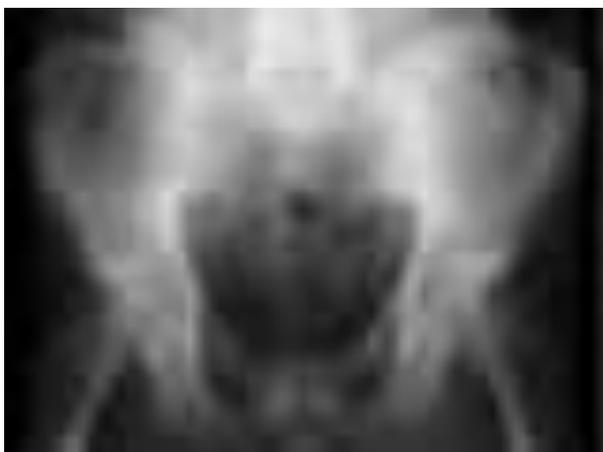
Radiograph pelvis; anteroposterior view. The x-ray shows normal bone density pattern. Both the hip joints are normal. Both the sacroiliac joints are normal.
